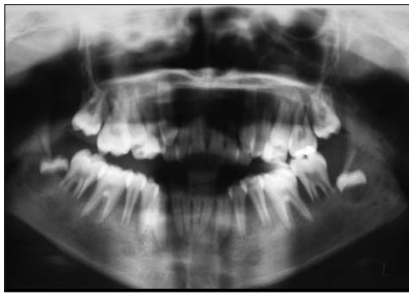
Orthopantomogram showing the displaced teeth germs of the lower third molars coronally and medially relative to their bony crypts. Severe alveolar bone resorption is visible around the lower second molars.
